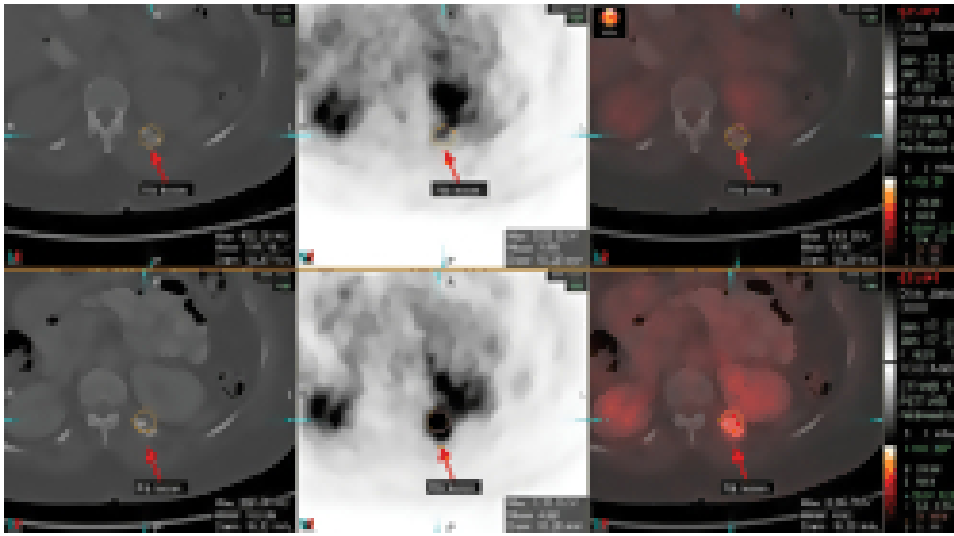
Example of a bone metastasis obtained combining CT and PET . Image adapted from [10].
